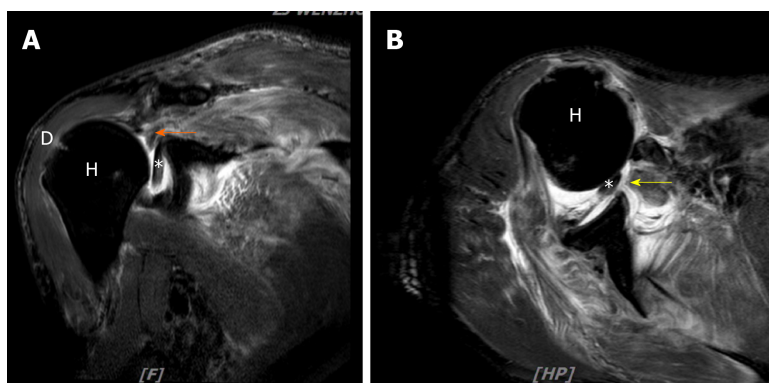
Magnetic resonance imaging of the right shoulder. A: Coronal T2 fat-suppressed image; B: Axial T2 fat-suppressed image showing a full-thickness tear of supraspinatus, infraspinatus subscapularis tendons, and interposition of long head bicep tendon. The orange arrow indicates supraspinatus tendon, and the yellow arrow indicates subscapularis tendons. H: Humeral head; D: Deltoid muscle; Asterisk: Long head bicep tendon.
